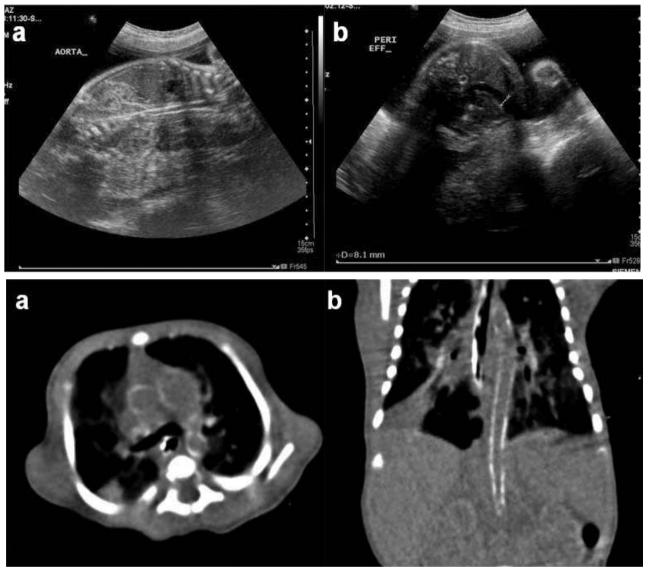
a) Prenatal sonogram showing the hyperechogenic renal artery and abdominal aorta, interpreted as calcifications. Increased renal echogenicity is also seen, b) Pericardial fluid and descending aorta calcification can be seen. Figure 2. — a) Axial CT image of the thorax showing circumferential calcification of the ascending and descending aorta, and the pulmonary trunk, b) Coronal reformation shows aortic calcification.
